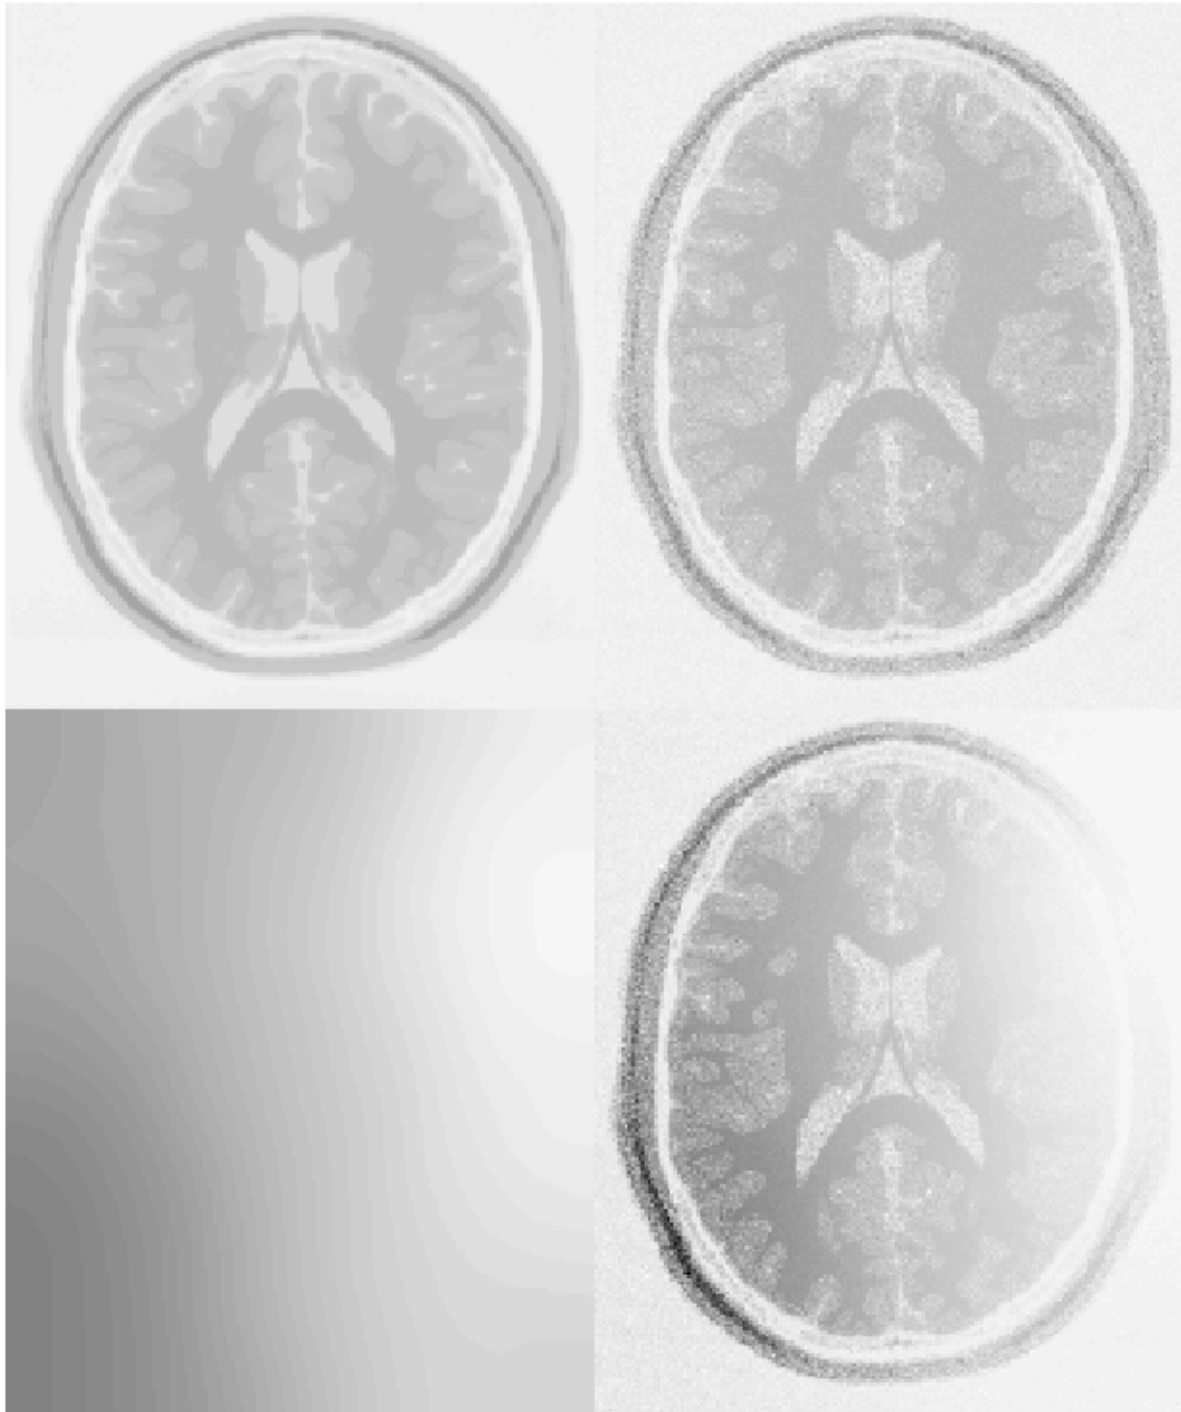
The MR images are modeled as a number of distinct clusters (top left), with different levels of Gaussian random noise added to each cluster (top right). The intensity modulation is assumed to be smoothly varying (bottom left), and is applied as a straightforward multiplication of the modulation field with the image (bottom right).
